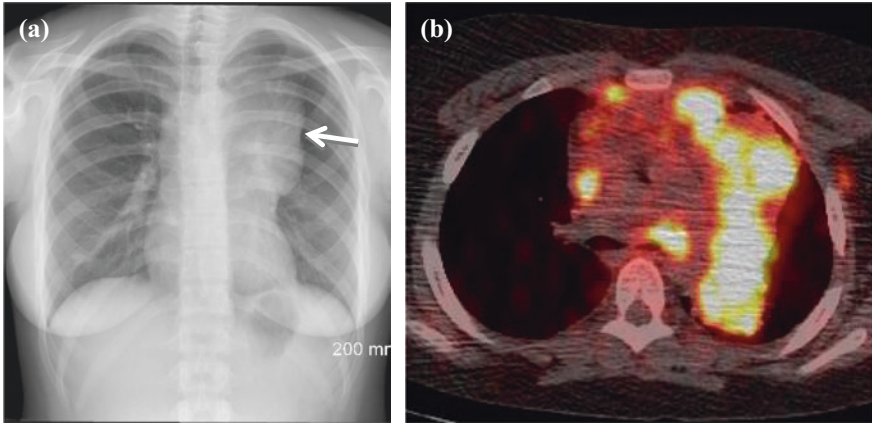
Chest radiograph (a) in a teenager who presented with weight loss and night sweats. The left mediastinal border is markedly abnormal with mass-like enlargement. A PET CT scan (b) shows intense uptake of FDG in the tumour. This is a non-Hodgkin's lymphoma treated with radiotherapy and chemotherapy
